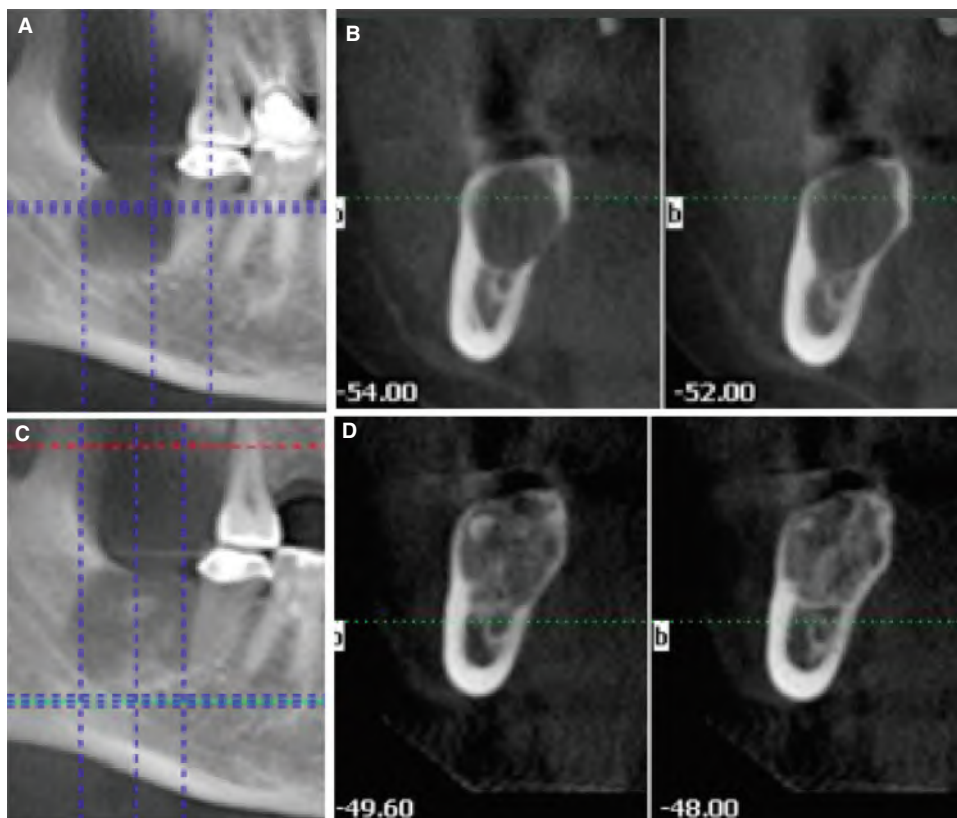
A. Panoramic reconstruction from a CBCT scan showing a well-defined radiolucency of the posterior mandible in an asymptomatic patient. B. Sagittal views reveal the expansile nature of the lesion and thinning of the cortical bone associated with this process. C & D. CBCT images taken 1 year later, showing internal calcification of the lesion and a more complex appearance than initial findings. Biopsy of the lesion confirmed a *benign fibro-osseous tumor* that explains the mixed radiographic appearance and well-defined nature of the process. (Courtesy of Dr. Yuan-Lung Hung, Los Angeles, CA.)
